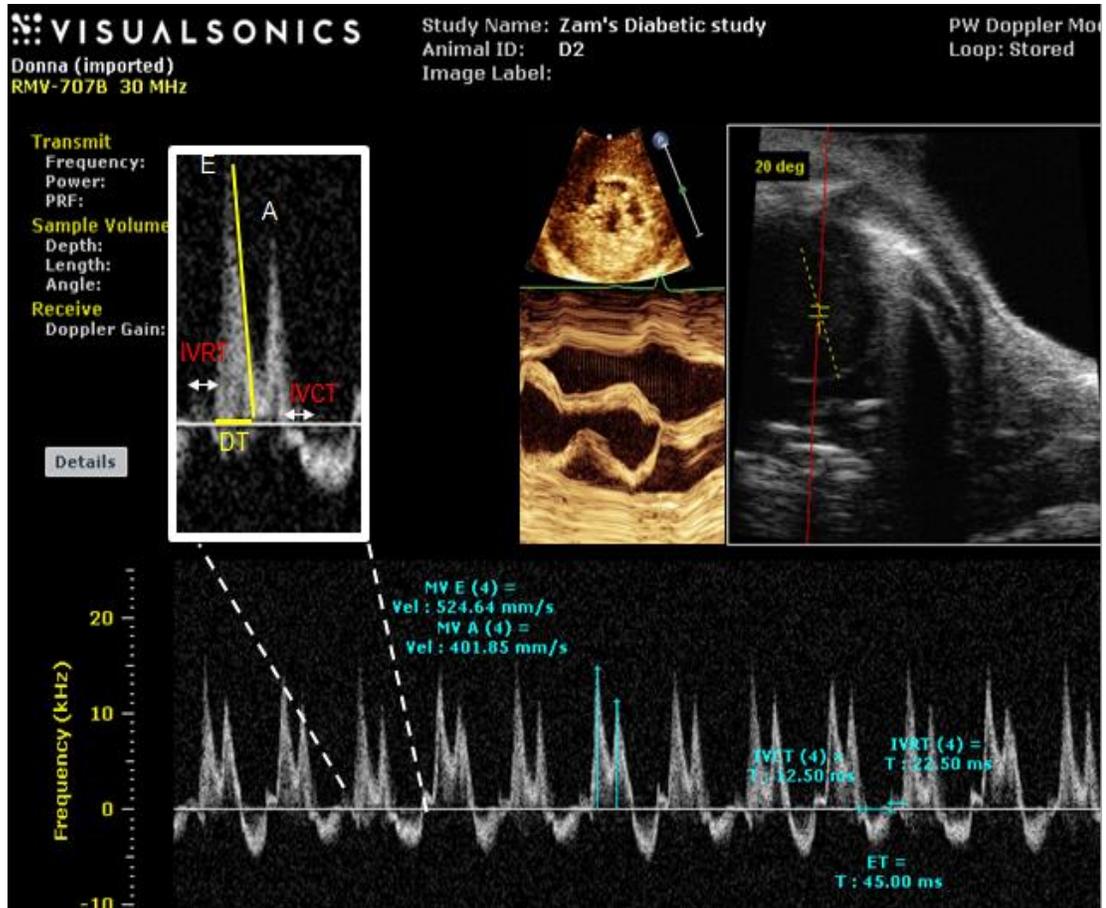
Representative image of the transmitral Doppler (TMD) imaging from a modified short axis (mitral view) in B mode.
